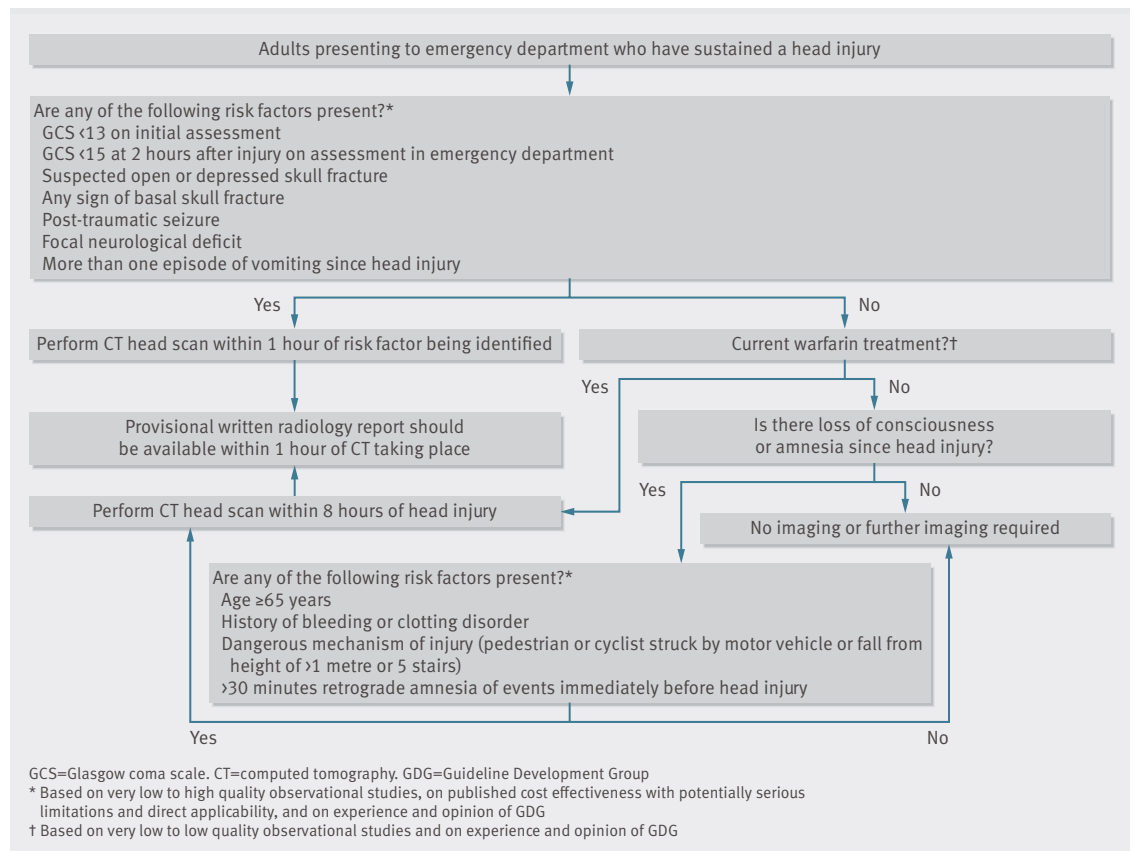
Algorithm 1: selection of adults for CT head scan
